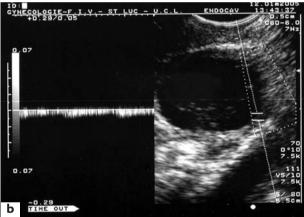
(a) Four and a half months after reimplantation, ultrasonography demonstrated the presence of a follicle of 9.2 mm in size, which reached 14 mm 3 days before the luteinizing hormone peak. (b) One week later, a corpus luteum of 21.2 mm was clearly visible, concomitant with the presence of a serum progesterone level of 6.5 ng/ml
